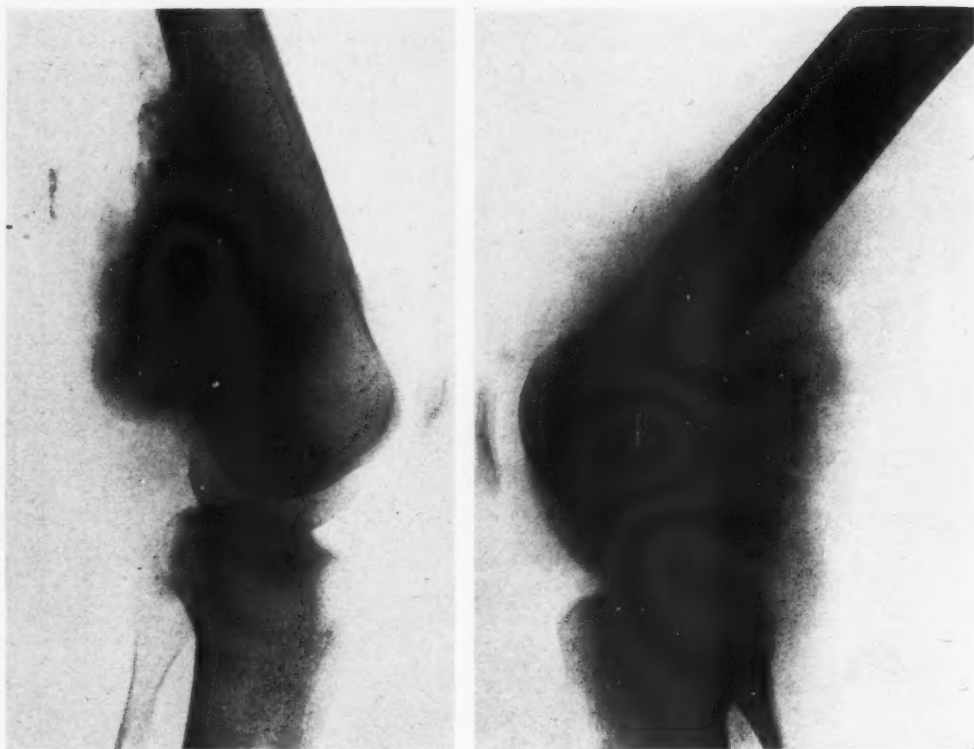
(left). Roentgenogram showing a typical sclerosing osteogenic sarcoma, with dense shaggy new bone formation beneath the periosteum in the metaphyseal region, and sclerosis of the marrow cavity.
